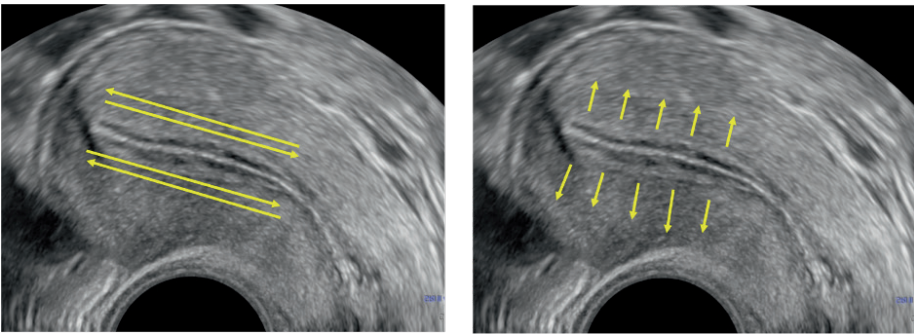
Ultrasound images of uterus in midsagittal section with depiction of contractions in the longitudinal (left) and radial (right) direction
